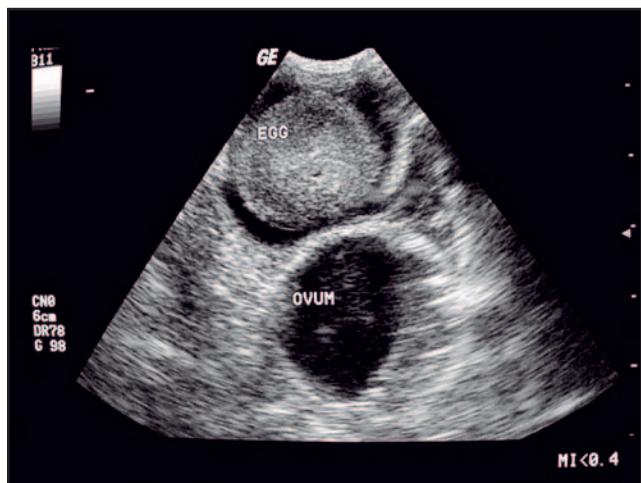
Coelomic ultrasound. An ectopic egg and uterine laceration were noted on laparotomy, and a salpingohysterectomy performed. Note the calcified egg in the caudal coelom and the ovum located more cranially (7.5-MHz probe). This ovum could not be detected on the radiographs. The hen recovered fully.
